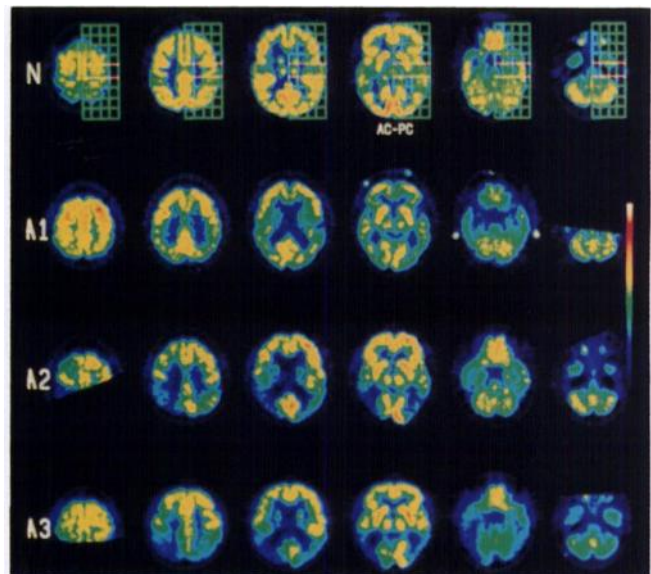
Indirect localization of functional abnormality. Three FDG PET image sets of patients with Alzheimer's disease (A1–3) were oriented to the stereotactic coordinates retrospectively and compared with corresponding planes of the normal stereotactic PET atlas (N). A1: 64-yr-old man with a clinical dementia rating (CDR) of 0.5; A2: 61-yr-old woman, CDR = 1.0; A3: 66-yr-old woman, CDR = 1.0.
